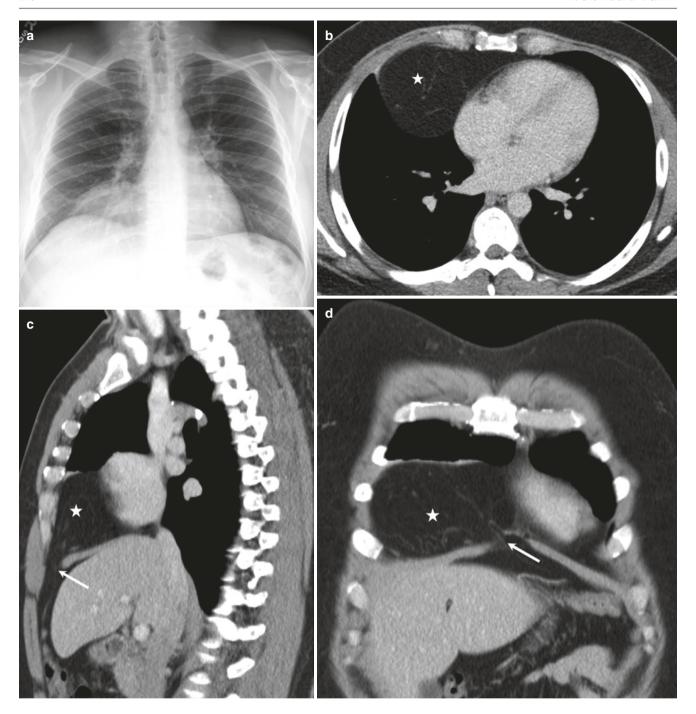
Fat-containing Morgagni hernia as a paracardiac mass. (a) Frontal radiograph shows a low-density right paracardiac mass. (b). Axial CT image confirms it to be a paracardiac fat pad (asterisk). (c, d)
